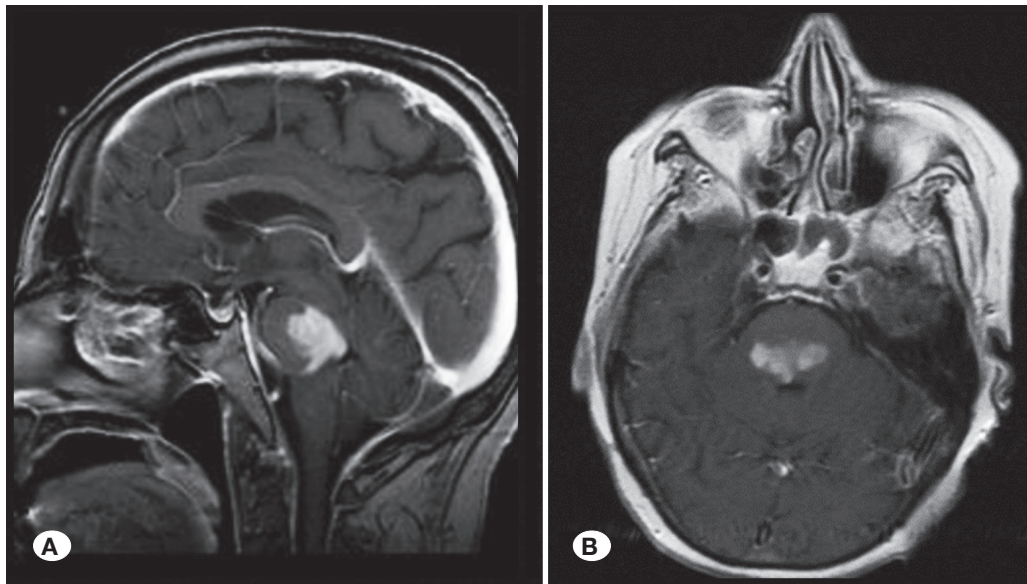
Sagittal (A) and axial (B) T1W contrast enhanced MR images show symmetric expansion of DIPGs in both transverse and vertical planes [image(s) courtesy of the authors' archive].
